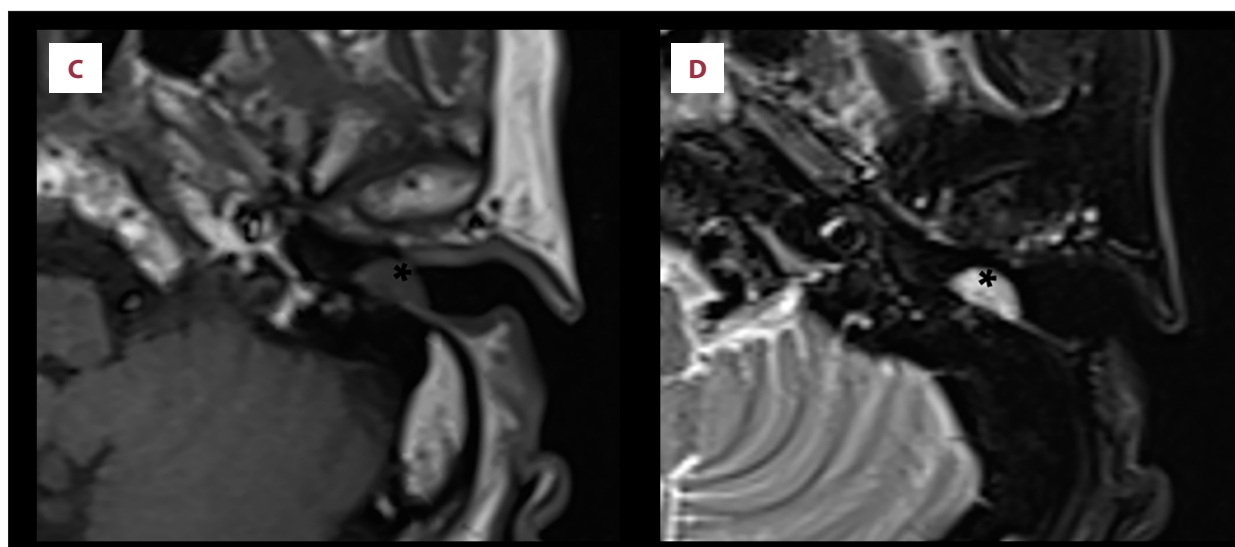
CT and MRI images in Case 1. (A, B) Coronal and axial CT scans showed soft-tissue masses in the left EAC, highlighting bony erosion at the adjacent posterior wall without involving the tympanic cavity. (C, D) T1-weighted and T2-weighted MRI of the EAC revealed a semicircular lesion along the posterolateral wall of the left EAC. The asterisk indicates the lesion. CT, computed tomography; MRI, magnetic resonance imaging; EAC, external auditory canal.
